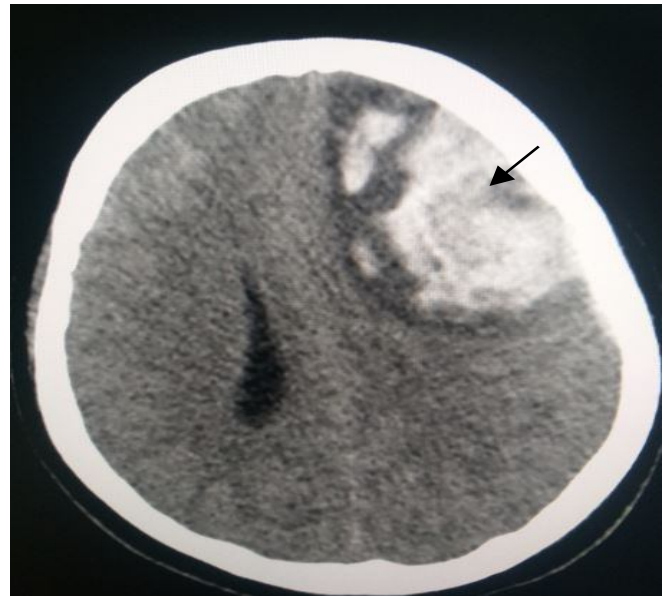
Non contrast computed tomography (NCCT) in axial view showing left frontal hemorrhage (arrow pointed) with mild extension into the frontal horn of left lateral ventricle with midline shift
